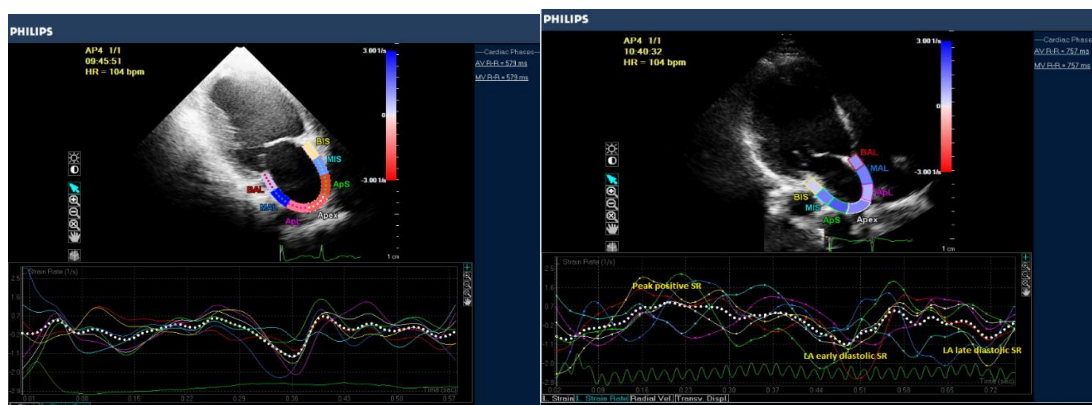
Two-dimensional echocardiography LA strain curves showing peak positive strain rate, early diastolic and late diastolic strain rates in a patient with DCM.
